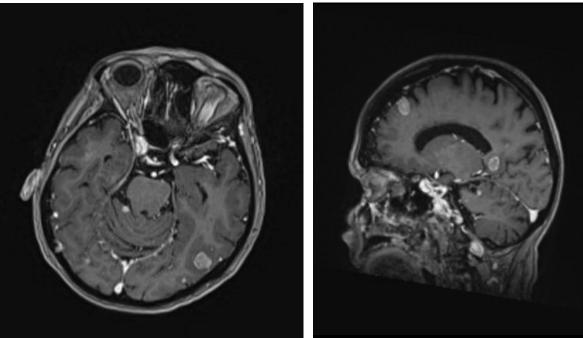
August 2023. MRI brain with and without contrast. Multiplanar, multisequential imaging of the brain. Multiple heterogeneously enhancing metastases throughout the bilateral cerebral and cerebellar hemispheres with associated vasogenic edema. The largest measure 1.3 cm in the left occipital lobe, 1.1 cm in the left medial cerebellar hemisphere, and 1.4 cm in the right anterior frontal lobe.
